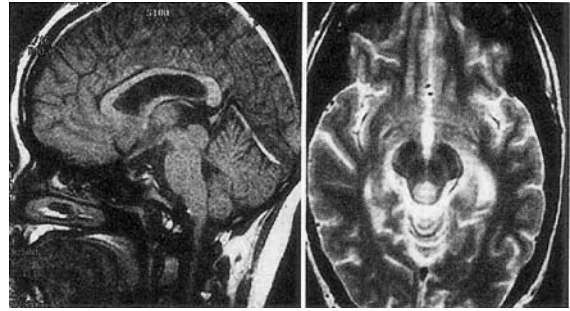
The typical magnetic resonance imaging appearance for a benign tectal glioma (Case 13). *Left:* Sagittal T₁-weighted image showing a globular tectal mass that is isointense with the surrounding brain and is occluding the aqueduct of Sylvius. The lesion showed no enhancement following administration of gadolinium. *Right:* On T₂-weighted imaging, the tumor is hyperintense in comparison to the surrounding brain.
